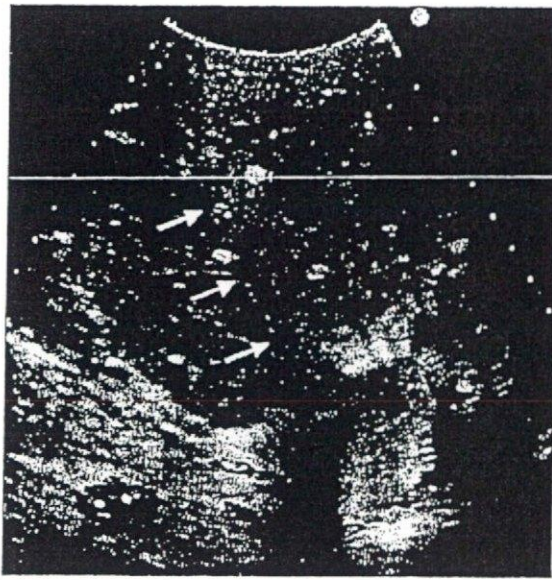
Intraoperative ultrasound after liver transection in a Group B donor. Note the hepatofugal flow to segment IV (arrows).
